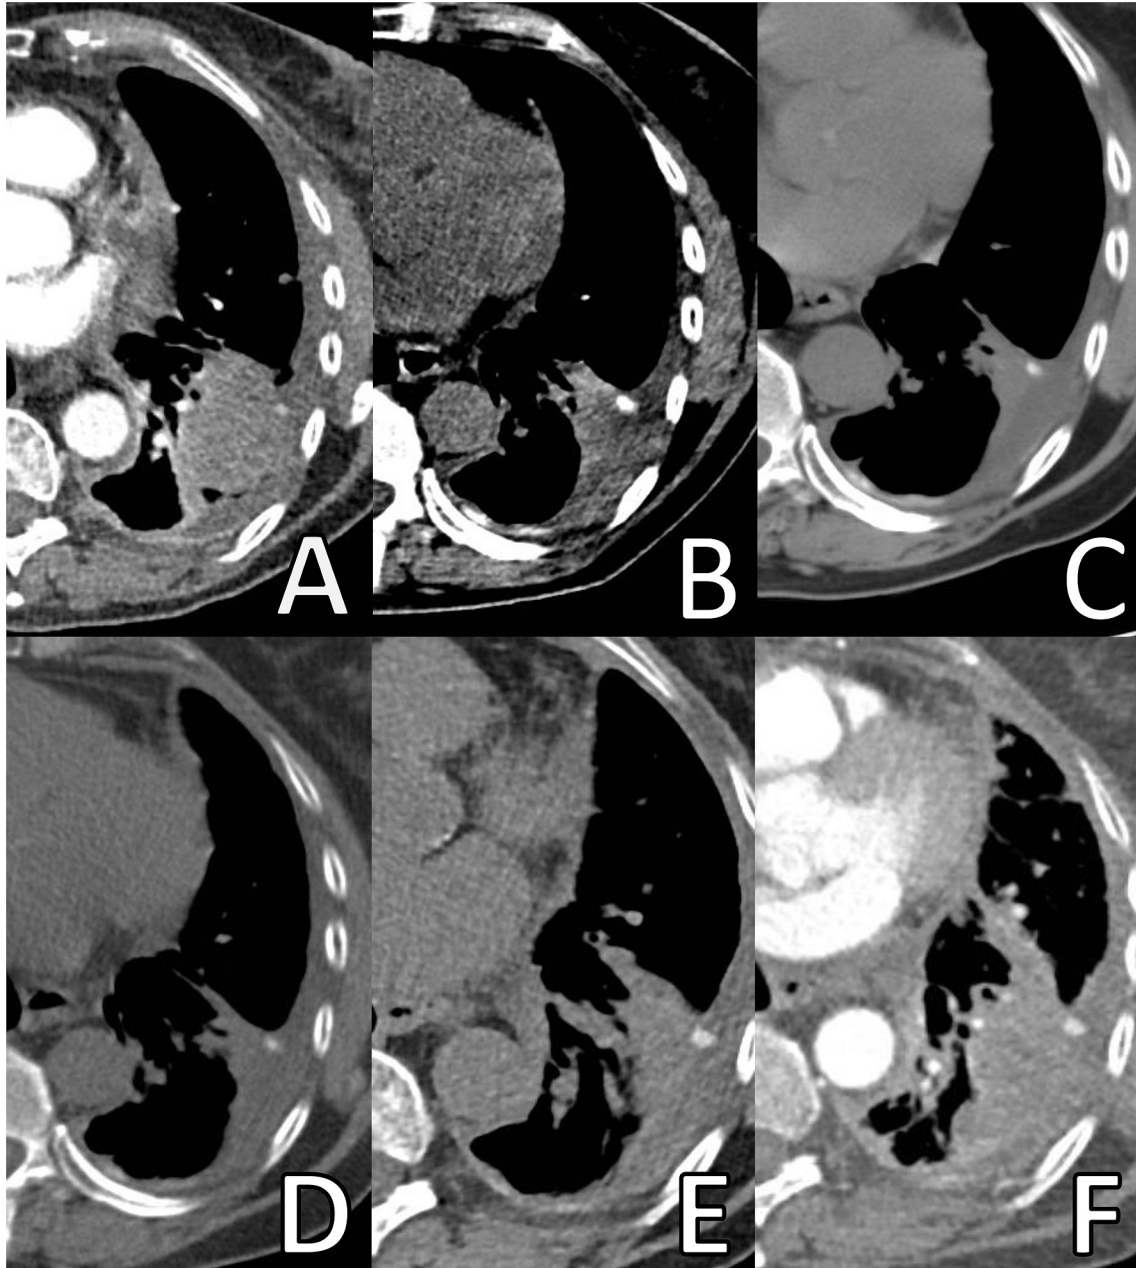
Primary tumour in the left lower lobe before, during and after osimertinib therapy. Consecutive CT scans demonstrating the primary tumour in the left lower lobe, adjacent to a pleural thickening and calcification caused by previous empyema. (A) Before osimertinib therapy. (B) Day 32 of osimertinib therapy, partial response. (C) Day 183, stable situation. (D) Day 241, slow progression. (E) Day 301, slow progression. (F) Day 350, rapid progression after cessation of osimertinib. CT, computed tomography.
